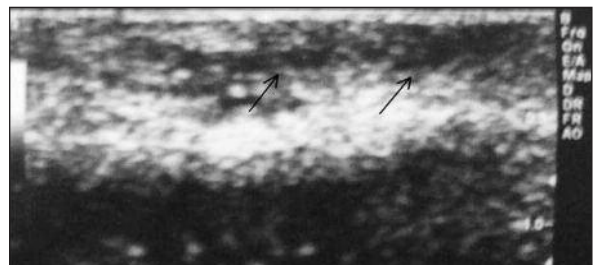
Doppler ultrasonographic examination of the superficial dorsal vein thrombosis.
